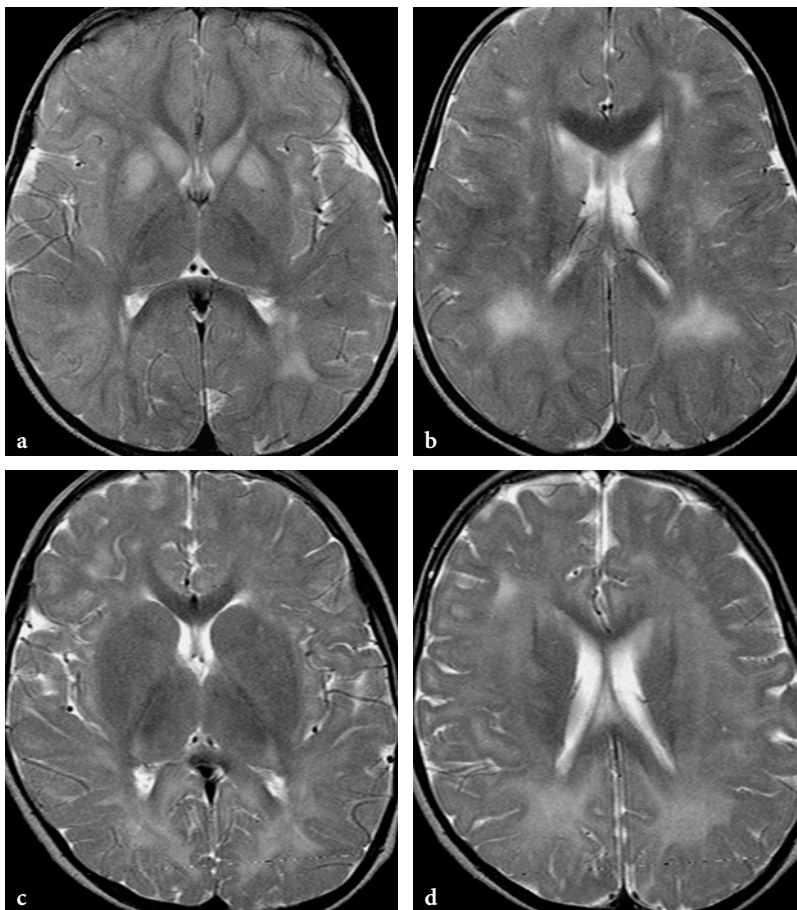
MR imaging manifestations in HMG coenzyme A lyase deficiency. a Axial T2-weighted fast spin-echo image in 3-year-old female patient after an episode of metabolic decompensation (parental neglect of dietary restrictions). Both gray and white matter lesions are present. The heads of the caudate nuclei and the anterior parts of the putamina are slightly swollen and exhibit ill-defined hyperintensities. Ill-defined white matter signal abnormalities are also present in the left occipital region; the subcortical U-fibers appear to be spared. b Axial T2-weighted fast spin-echo image in the same patient. On this image, white matter abnormalities are more extensive and prominent. c Axial T2-weighted fast spin-echo image in another, 4-year-old female patient. In this case, the basal ganglia are normal, except for very subtle signal changes suggested within the globi pallidi. d Axial T2-weighted fast spin-echo image in the same patient. White matter signal changes are more extensive, and the subcortical U-fibers appear to be involved as well
